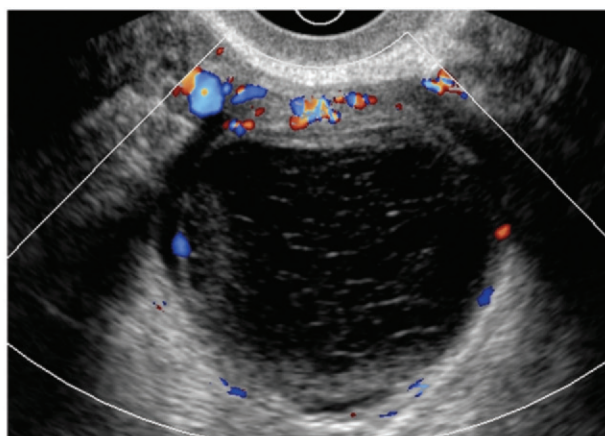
Hemorrhagic cysts. (a) Coronal transvaginal color Doppler US image of the ovary demonstrates echogenic, avascular, heterogeneous nonshadowing material compatible with acute blood clot. (b) Coronal transvaginal color Doppler US image of the right ovary in a different patient demonstrates a cyst with a solid-appearing mural nodule. The nodule is avascular with concave edges, findings that are characteristic of a retracting clot. At real-time imaging, the clot, which was relatively soft, “jiggled” with transducer ballottement. (c) Sagittal transvaginal color Doppler US image of the left ovary in a third patient demonstrates a cystic structure with avascular irregular fine linear echoes that represent fibrin strands in a resolving hemorrhagic cyst.
